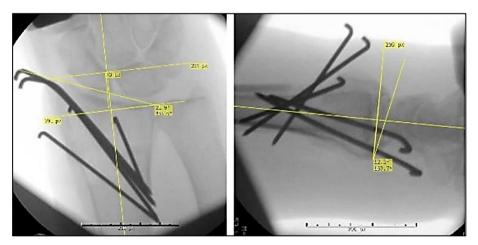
Perioperative X-ray pictures.
